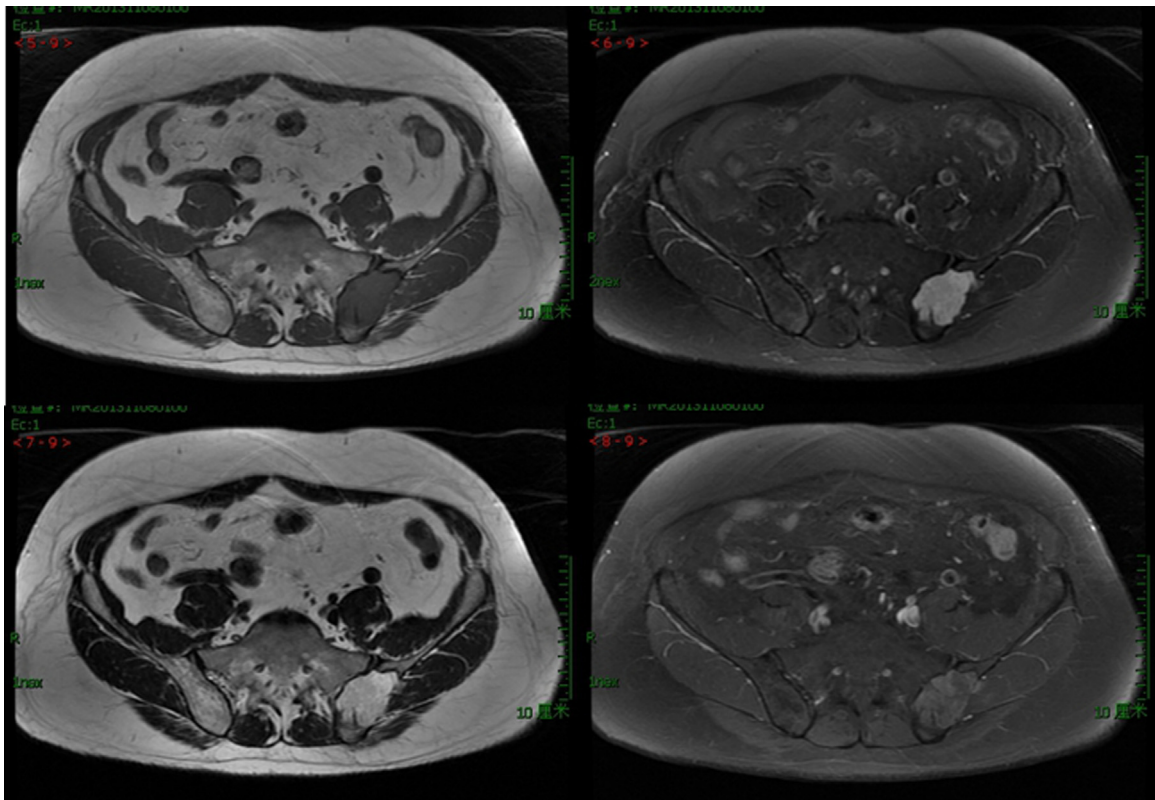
Preoperative MRI showed moderate signal on T1 and high signal on T2 with inhomogeneous enhancement.
